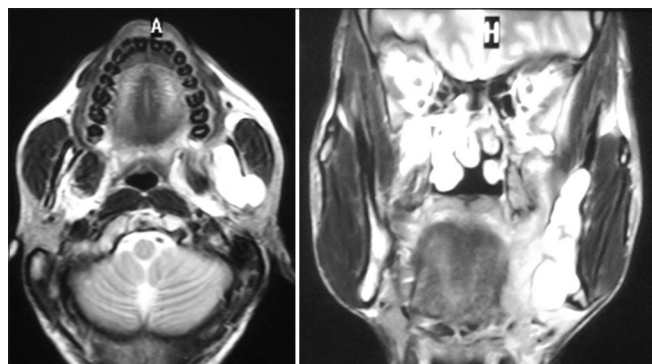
Axial (left) and coronal (right) sections of magnetic resonance imaging of the patient showing lesion involving the left side of the mandibular ramus
